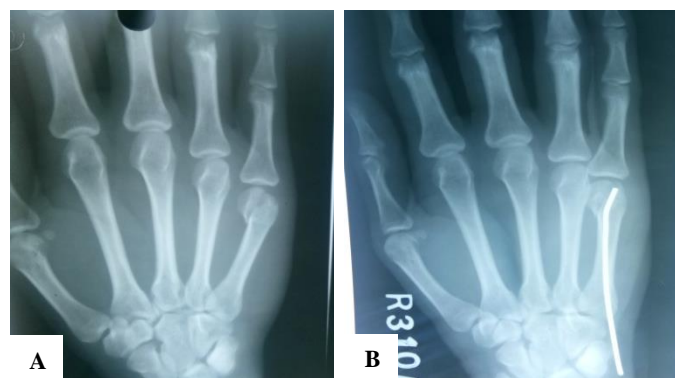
(A) Preoperative radiograph showing the angulation of the neck of the fifth metacarpal; (B) the angle being corrected by the bent k-wire introduced in antegrade manner.
